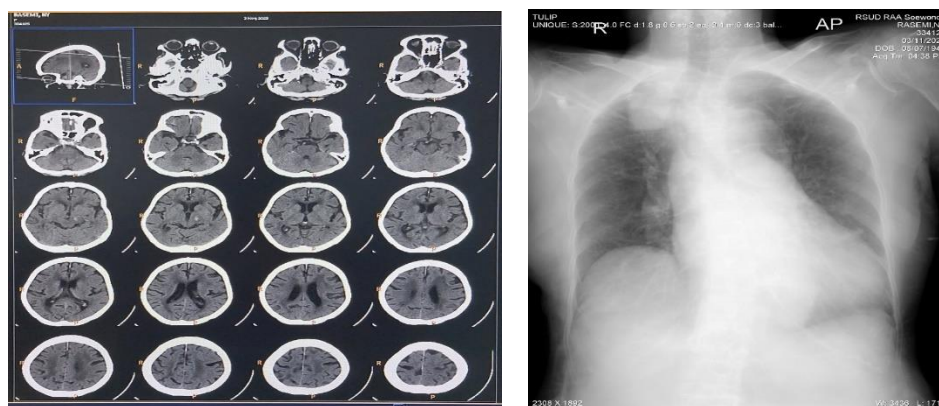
Supporting examination non-contrast head CT-Scan and AP chest x-ray
